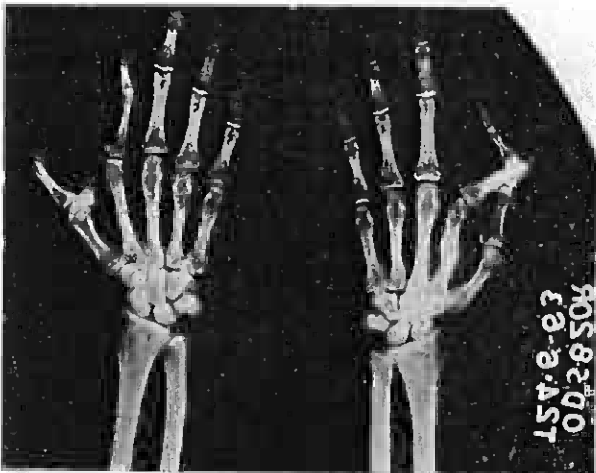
The X-rays of the hands of Case I. Note that in the left thumb there are three phalanges and a tendency towards a bifid thumb (polydactyly). In the right hand note that 'bifid' index.
